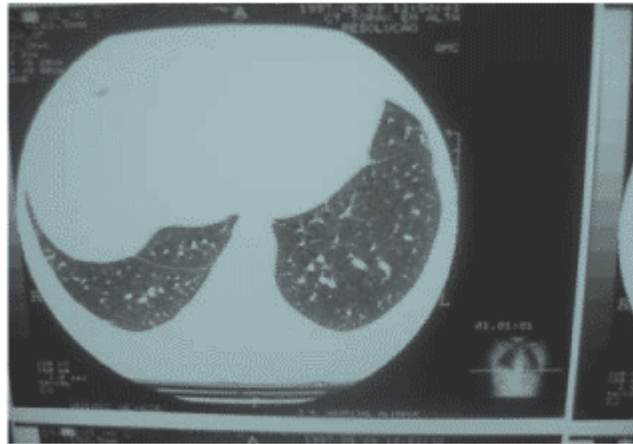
Shrinking Lung Syndrome: lower cross-sectional view from chest computed tomography revealing no evidence of interstitial alterations
